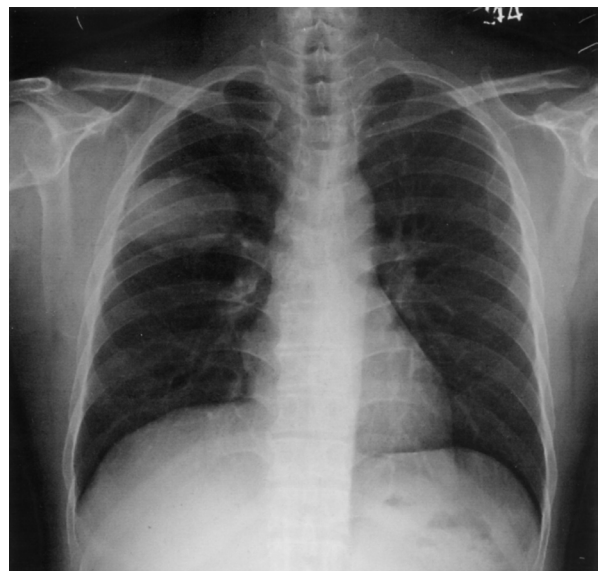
Chest X-ray. A round, homogenous, well-defined solitary pulmonary nodule noted on the right upper lung chest X-ray image.
